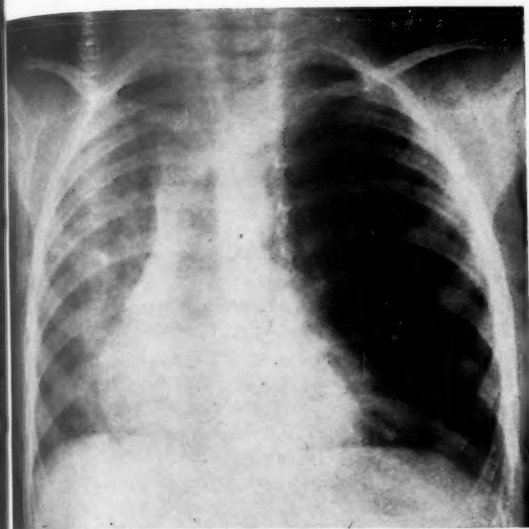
Case 1. Radiograph of the chest taken on February 29, 1952, showing reduction in the mediastinal shift and some re-expansion of the left lower lobe. The left upper lobe remains emphysematous.
